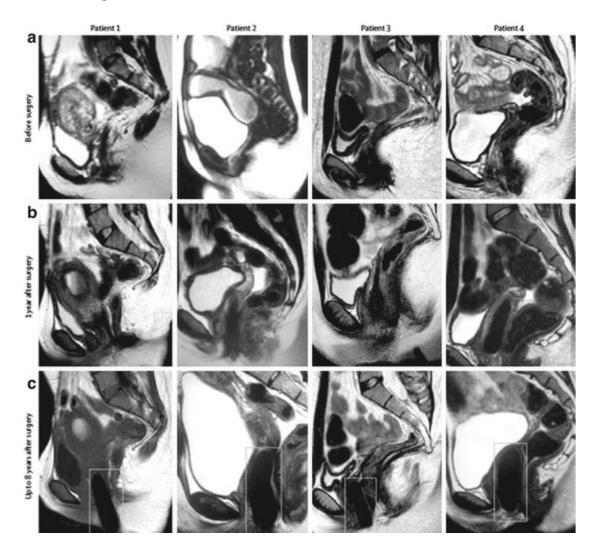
Preoperative and Postoperative MRI images. (a) Preoperative MRI images show absence of vaginal organs. (b) MRIs 1 year after surgery show engineered vaginal organs. (c) Latest MRI images up to 8 years after surgery (boxes within the MRIs show engineered vaginal organs)
